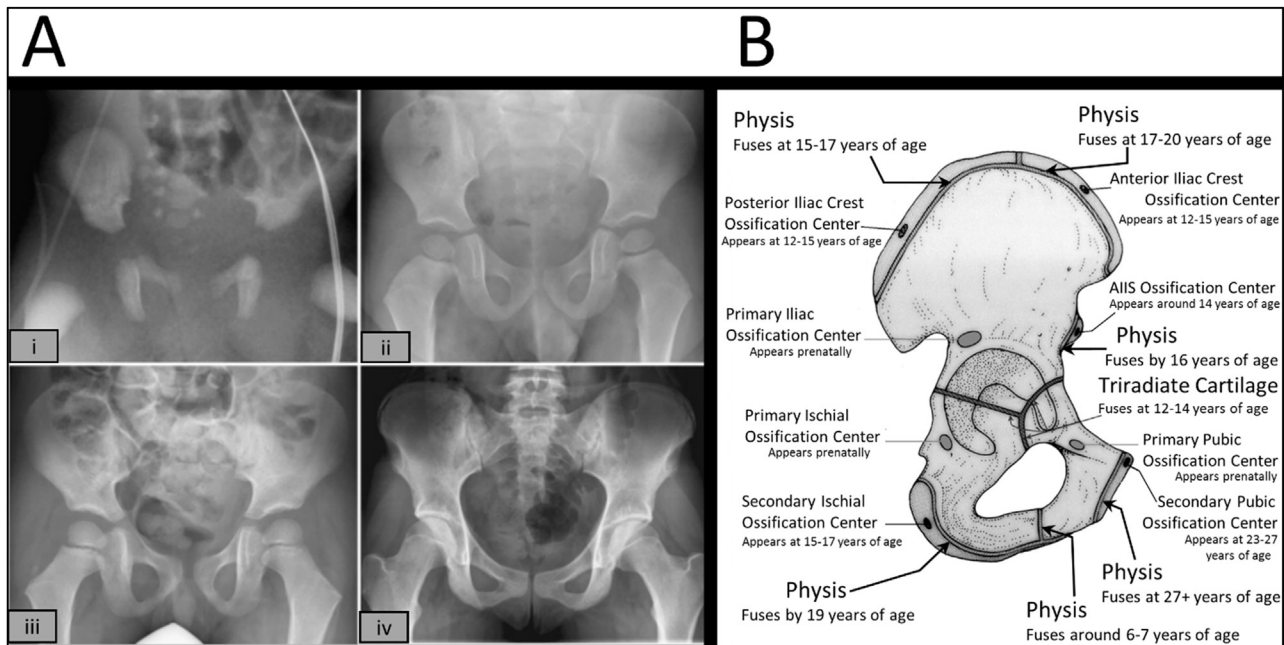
(A) Normal pelvic bone anatomy and development shown on radiographs at birth (i), 2 years of age (ii), 5 years of age (iii), and 15 years of age (iv). (Adapted with permission from Donnelly.²¹) (B) The location of ossification centers in the pelvic bone, noting when they appear and when physes fuse. Note the Y-shaped triradiate cartilage at the acetabulum. (Adapted with permission from Scheuer and Black²² using information from McCarthy et al.⁴)
